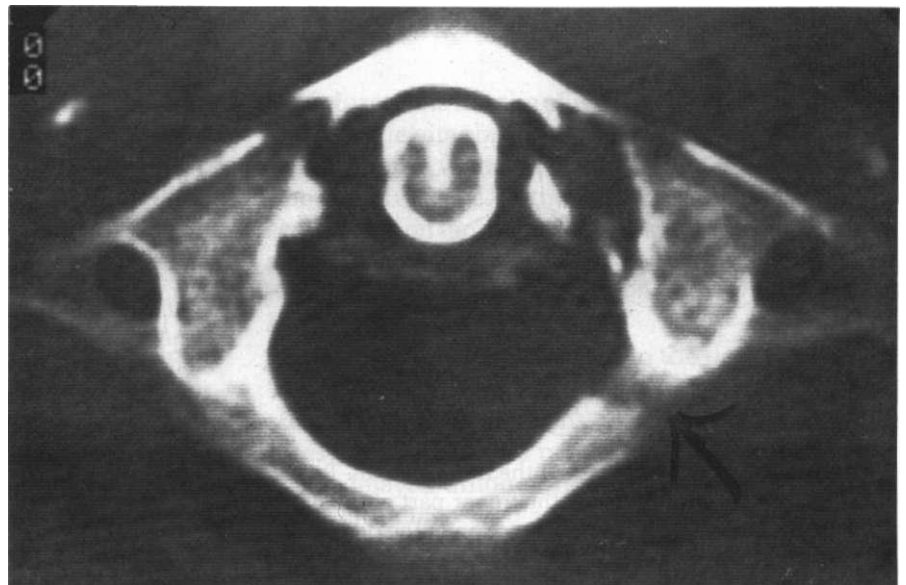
This three-part fracture is much more common than the four-part fracture that carries the Jefferson eponym. (Radiograph courtesy of Professor George Alker, M.D.)
